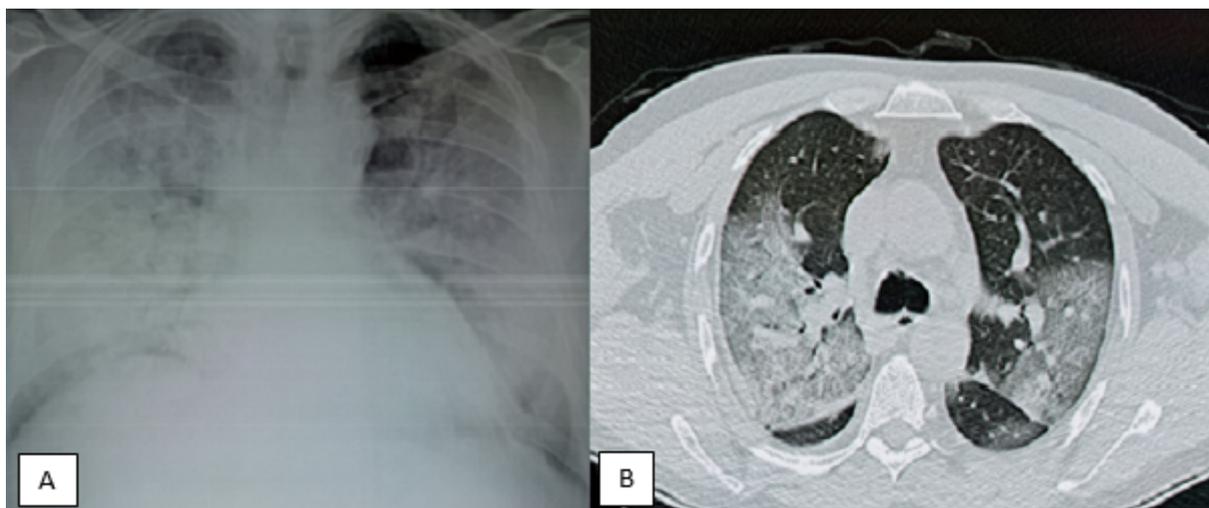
(A,B). PA radiography and thorax tomography revealed ground glass-consolidation areas and linear atelectasis
